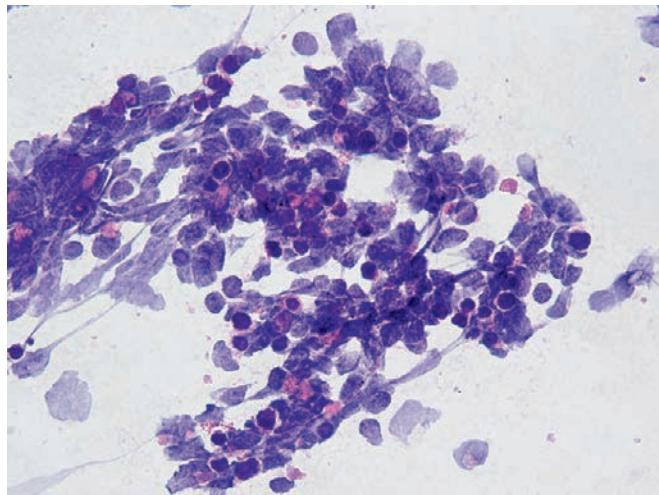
Small cell carcinoma smear from endobronchial ultrasound-guided fine-needle aspiration of subcarinal lymph node.
